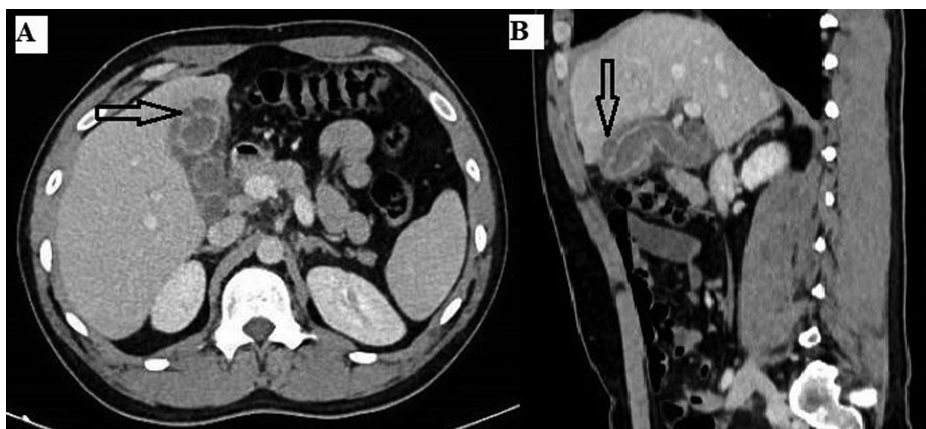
Abdominal CT images were taken at the first admission of a 50-year-old male patient diagnosed with gallbladder perforation intraoperatively. (A) Axial CT image, postcontrast venous phase. (B) Sagittal CT image, postcontrast venous phase. It shows significant thickening and contrast enhancement in the gallbladder wall; diffuse edema in the pericholecystic area; irregularity in the gallbladder wall and a focus of perforation. CT, computed tomography.
